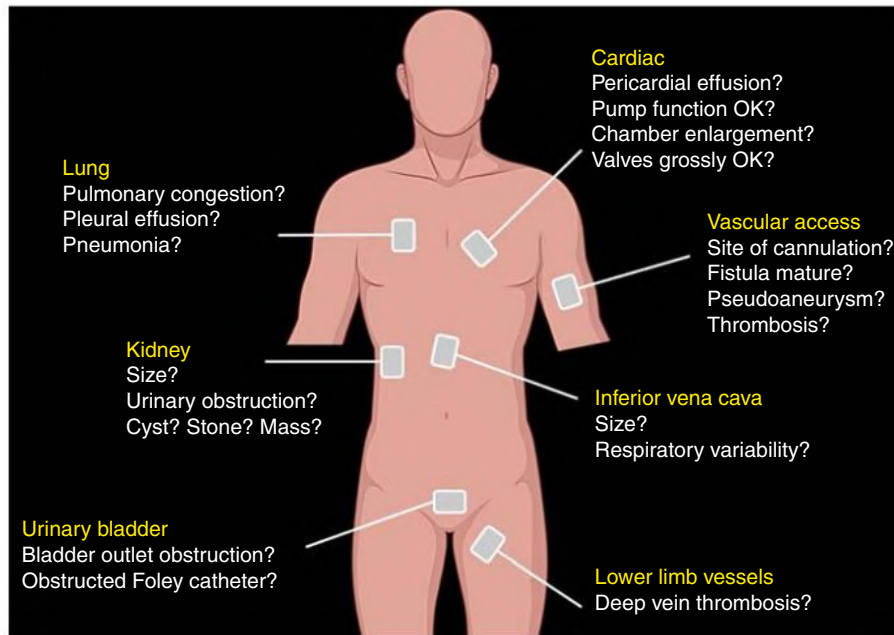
Common sonographic applications and focused questions encountered in nephrology practice. (Created with Biorender.com.)
